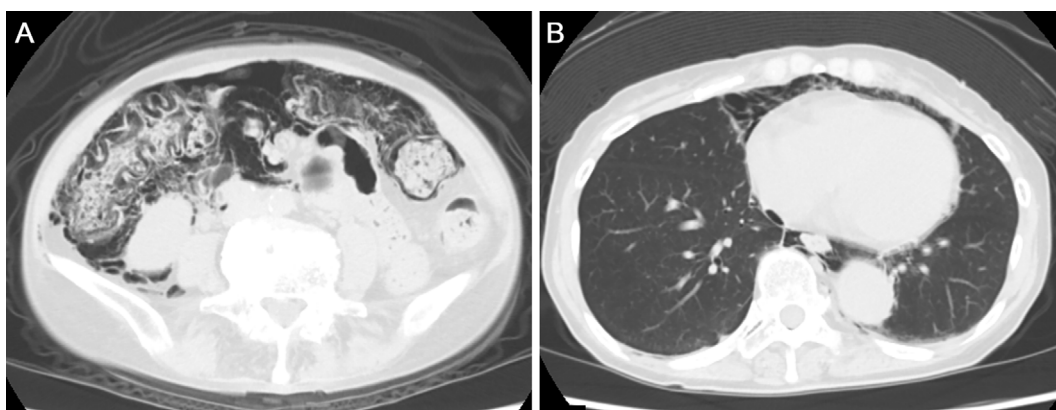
CT images. CT performed one month after the colonoscopic examination shows the presence of gas in the wall of the large intestine and pneumoperitoneum (A). Mediastinal emphysema is also noted (B).
